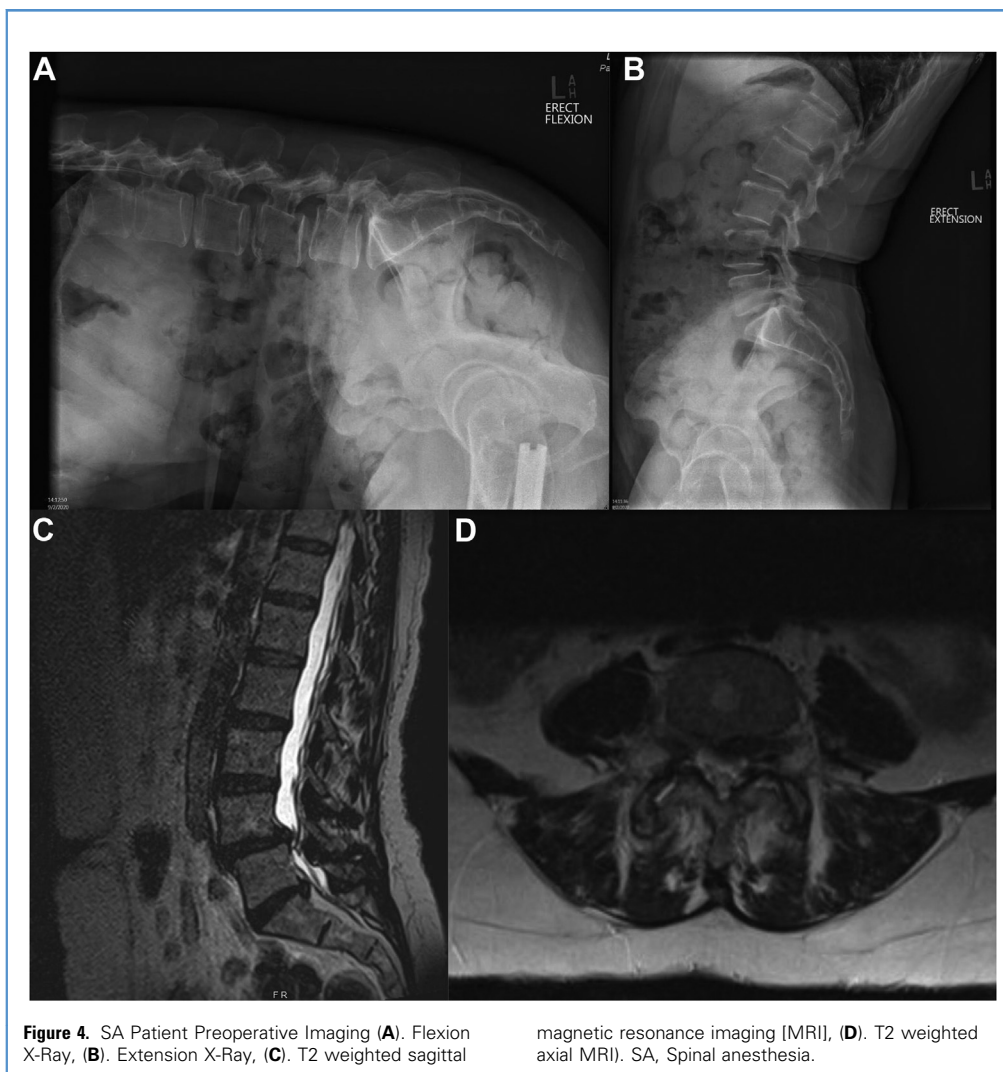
SA Patient Preoperative Imaging (A). Flexion X-Ray, (B). Extension X-Ray, (C). T2 weighted sagittal
